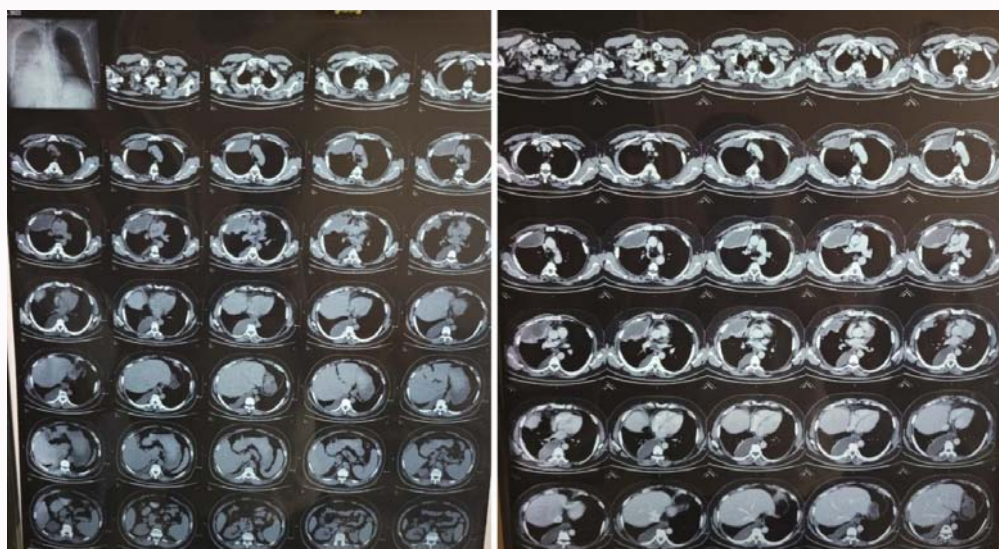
(A): CT Chest plain with contrast.
